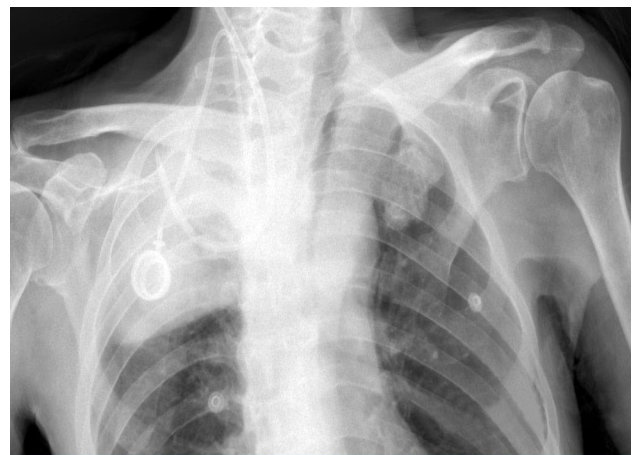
Chest radiograph demonstrating interposition of the right dialysis catheter.
